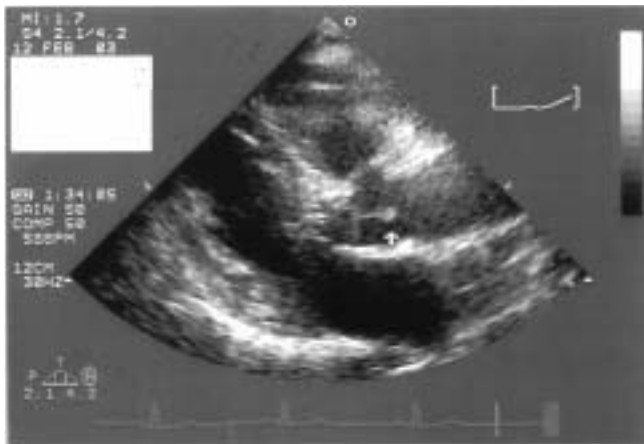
Transthoracic echocardiogram showing a stalked papillary fibroelastoma attached to the aortic valve.
